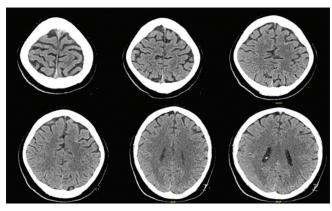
Axial computed tomography head without contrast shows resolution of previously shown lesions
